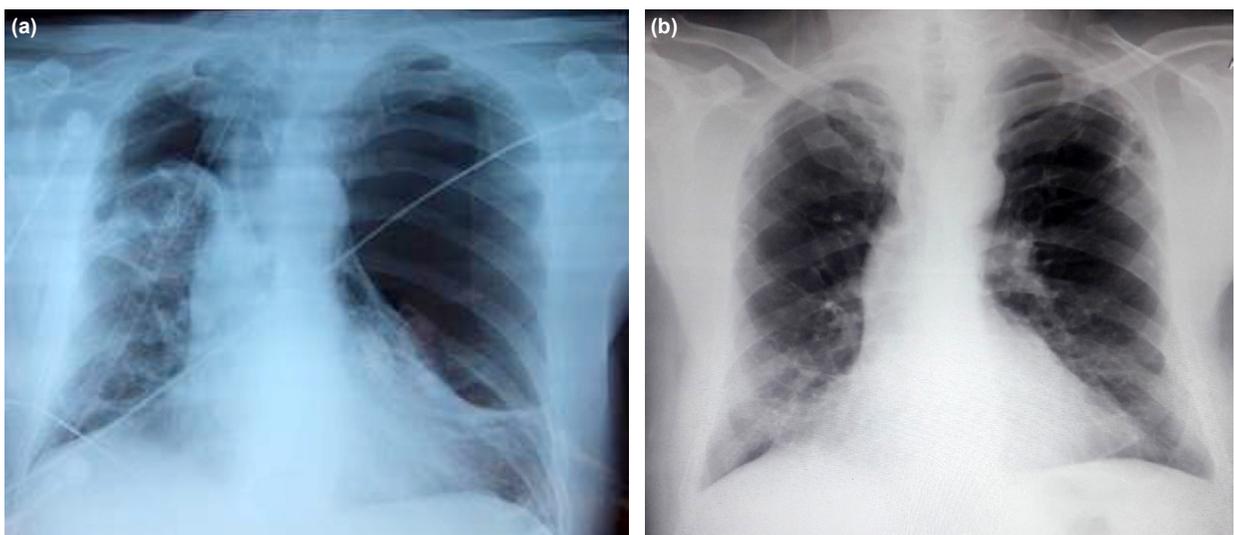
(a) PA Chest X-ray taken on postoperative 13th day; it appears that the right lung cannot be expanded. (b) PA chest X-ray taken after surgery performed on both sides.
